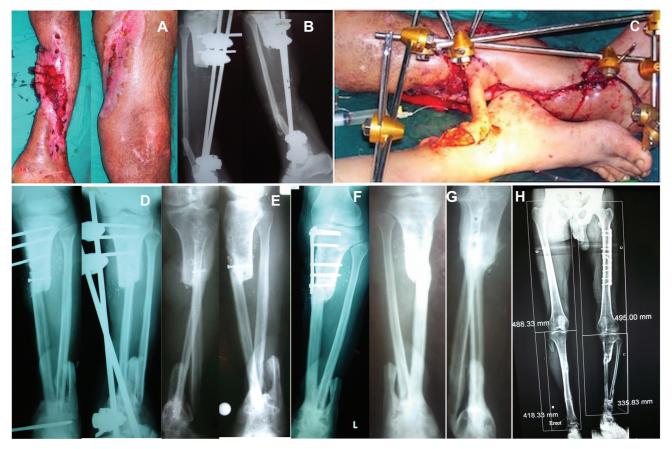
(A) Left tibial defect after ipsilateral femoral plating and reconstruction of the popliteal artery using vein graft. (B) Radiographs demonstrating 20-cm tibial bone defect. (C) Immediate postoperative photograph. (D) Immediate postoperative radiographs. (E) Three-month postoperative radiographs showing proximal and distal union of the fibular graft. (F) One-year postoperative radiograph demonstrating healed derotation osteotomy of the proximal tibia. (G) Anteroposterior and lateral radiographs following plate removal. (H) Standing radiographs of both limbs showing 7.5-cm shortening.
